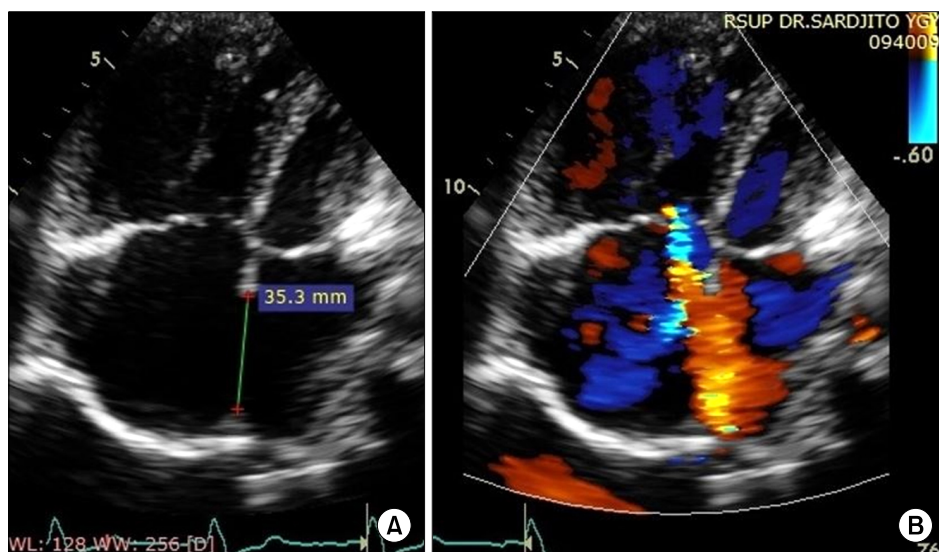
(A, B) Transthoracic echocardiogram showing a large tissue defect of 35 mm, with a bidirectional shunt through the interatrial septum.
